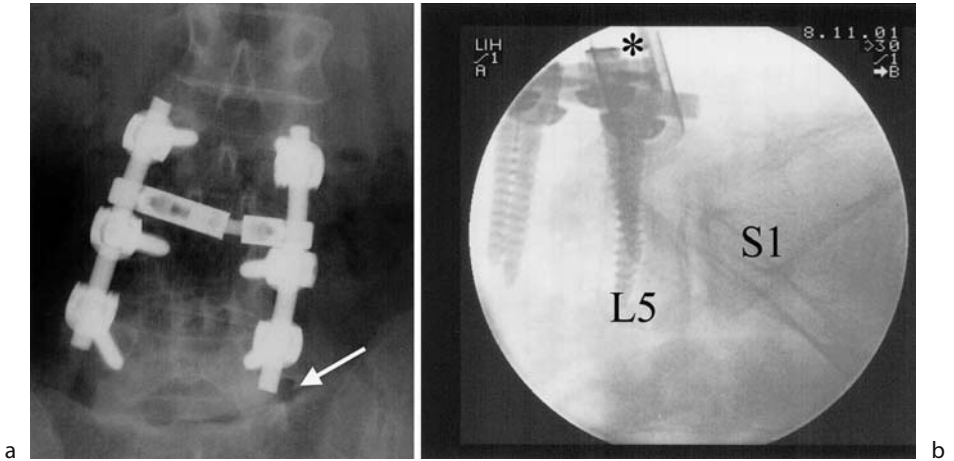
Images of a 58-year-old woman with left L5-S1 extraforaminal lumbar disc herniation (arrow) who underwent L3-4 and L4-5 posterior lumbar interbody fusion (PLIF) using posterior instrumentation 2 years before the onset of symptoms. a Anteroposterior radiograph showing L3-4 and L4-5 PLIF using posterior instrumentation. b Lateral fluoroscopic view of tubular retractor placement (asterisk) for left L5-S1 extraforaminal lumbar disc herniation
